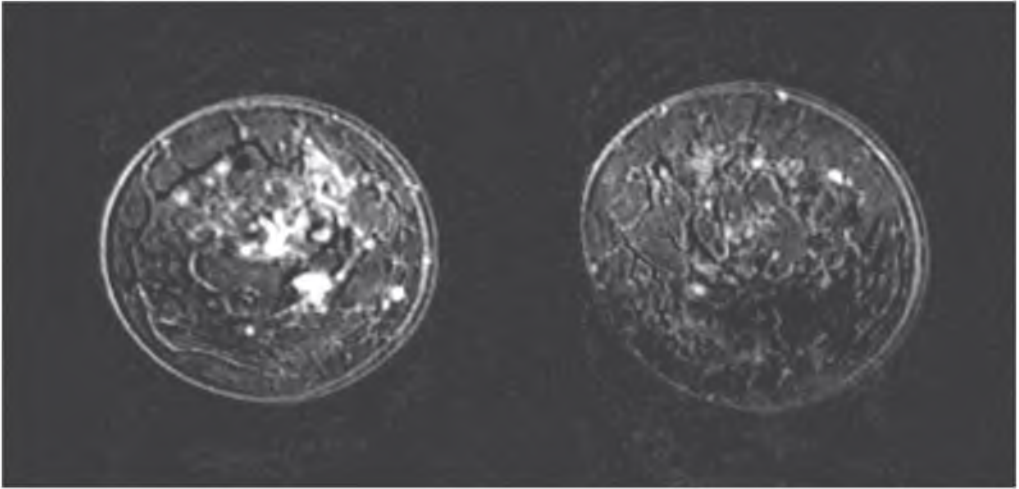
Multiple small enhancing foci on a subtracted high resolution MR image in the right breast, representing a large multicentric ILC in the right breast.
